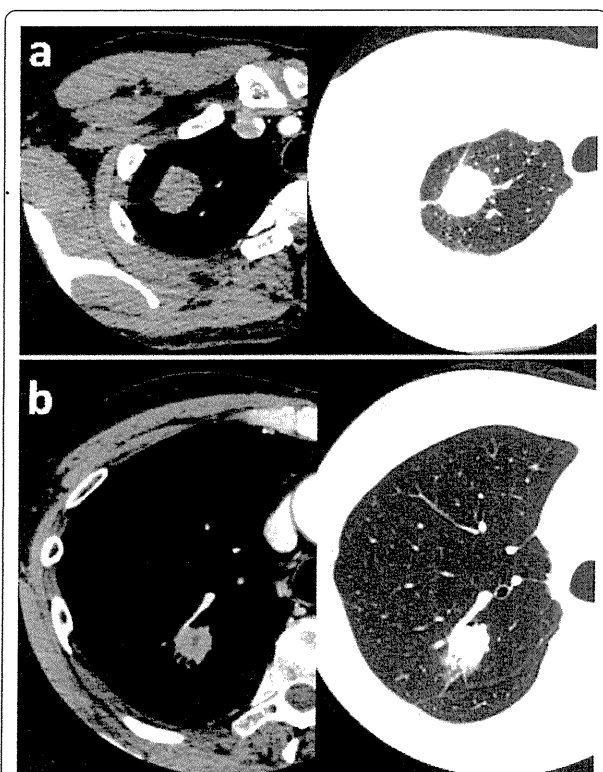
Enhanced chest CT of the lung. Chest CT of case 1 (a) and case 2 (b) showed a tumor of the right upper lobe of the lung. (a) Chest CT revealed a tumor with pleural indentation, without ground glass opacity (GGO). The tumor was 32 mm in diameter and mildly enhanced. (b) Chest CT revealed a nodule with GGO, pleural indentation, air bronchogram and venous involvement. The nodule was 29 mm in diameter and mildly enhanced.
